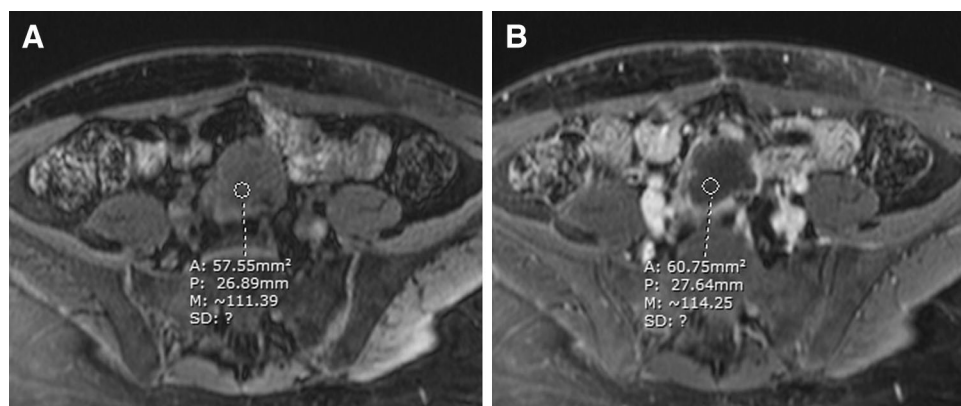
20-year-old woman with complete pancreatic necrosis of the transplanted pancreas. A, B Transverse T1-weighted image with fat saturation (A) shows mean signal intensity (SI) of 111.4 at 1 min post-contrast enhancement (B) shows mean SI of 114.3 at 5 min providing a mean percentage of parenchymal enhancement (MPPE) of 2.6%.
